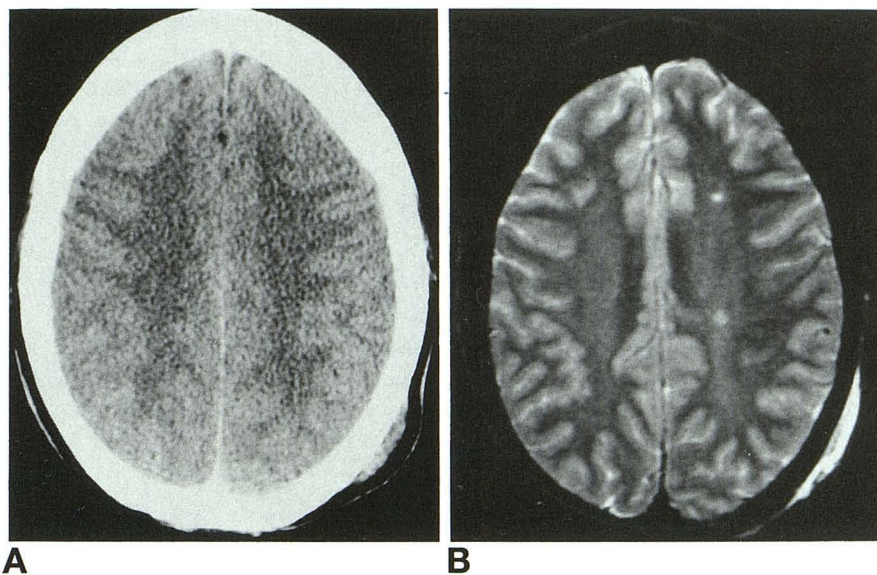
A, There is no evidence of abnormality on head CT of a 20-year-old woman after mild head injury caused by an assault.
